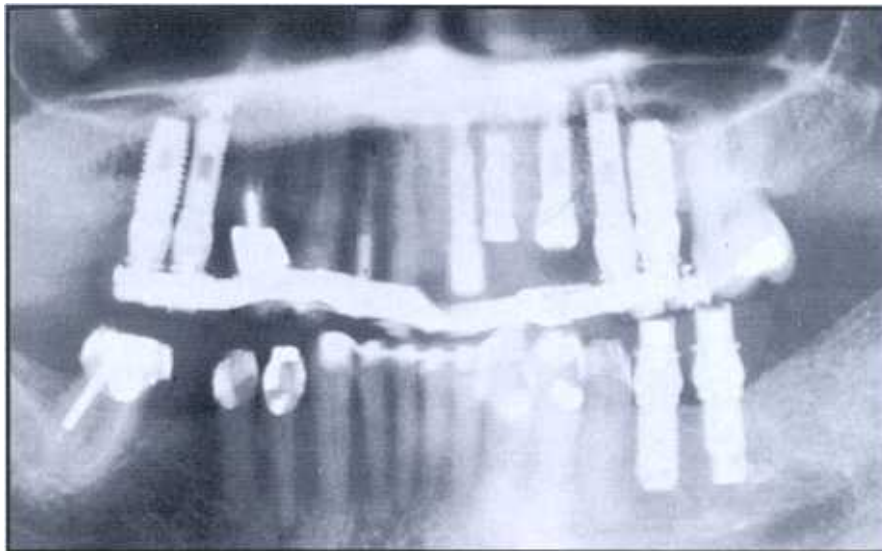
Radiograph following placement of all implants and initiation of orthodontic therapy.
